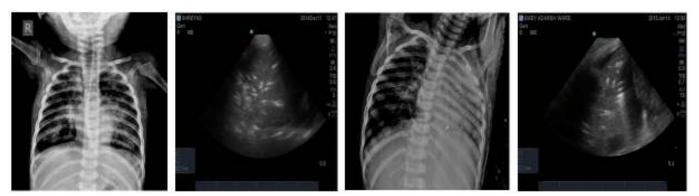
X-ray and USG Images showing two positive cases of Pneumonia
